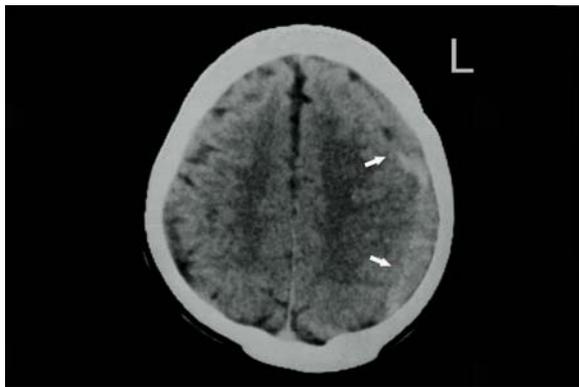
On computed tomography, a frontooccipital isodense subacute subdural hematoma (arrows) is delineated.
